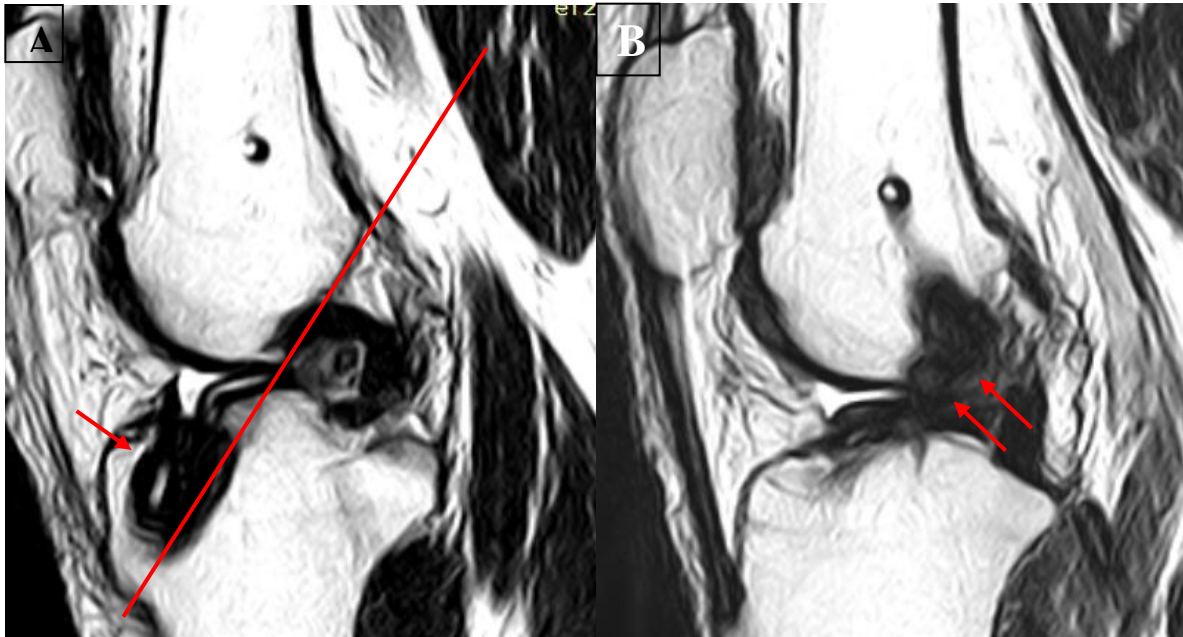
(A&B). Too anterior tibial tunnel & Roof impingement. Sagittal T2-weighted image showing the tibial tunnel anterior to the Blumensaat line. The graft appears posteriorly bowed (arrows) with increased signal.
